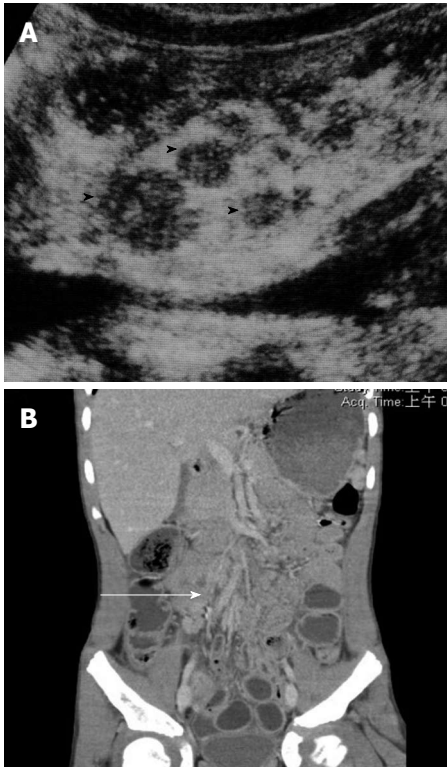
Mesenteric adenitis. A: Ultrasound shows multiple enlarged lymph nodes (arrowheads) at the base of mesentery, anterior to the inferior vena cava; B: Computed tomography of the abdomen showing clustering of mesenteric lymph nodes with largest diameter of about 11.2 mm (black arrow) and thickening of the bowel wall of terminal ileum.
